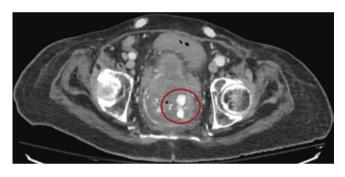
CTA showing contrast extravasation in the upper rectum
